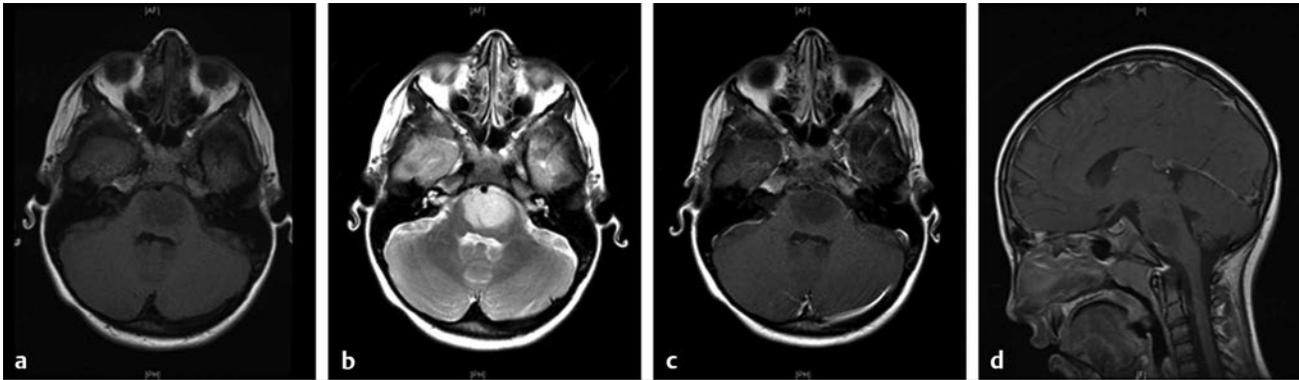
Diffuse intrinsic pontine glioma (DIPG). (a) Axial T1-weighted magnetic resonance (MR) image of a child with DIPG demonstrating classic hypointensity and indistinct margin. (b) Axial T2-weighted MR image of the same patient demonstrating classic hyperintensity. (c) Axial T1-weighted MR image with gadolinium contrast demonstrating lack of enhancement. (d) Sagittal T1-weighted MR image with gadolinium contrast.
